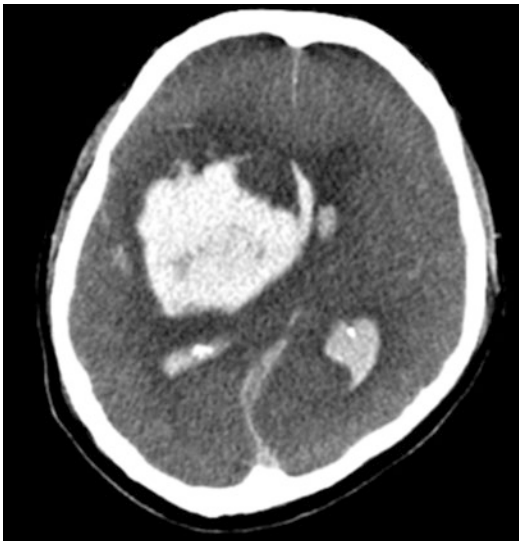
Axial brain computed tomography (CT) image of the intracerebral hemorrhage. The center of the high-density mass is in the right basal ganglia area, compatible with typical hypertensive intracerebral hemorrhage. Complicating intraventricular hemorrhage and subfalcine herniation are also noted in this image
